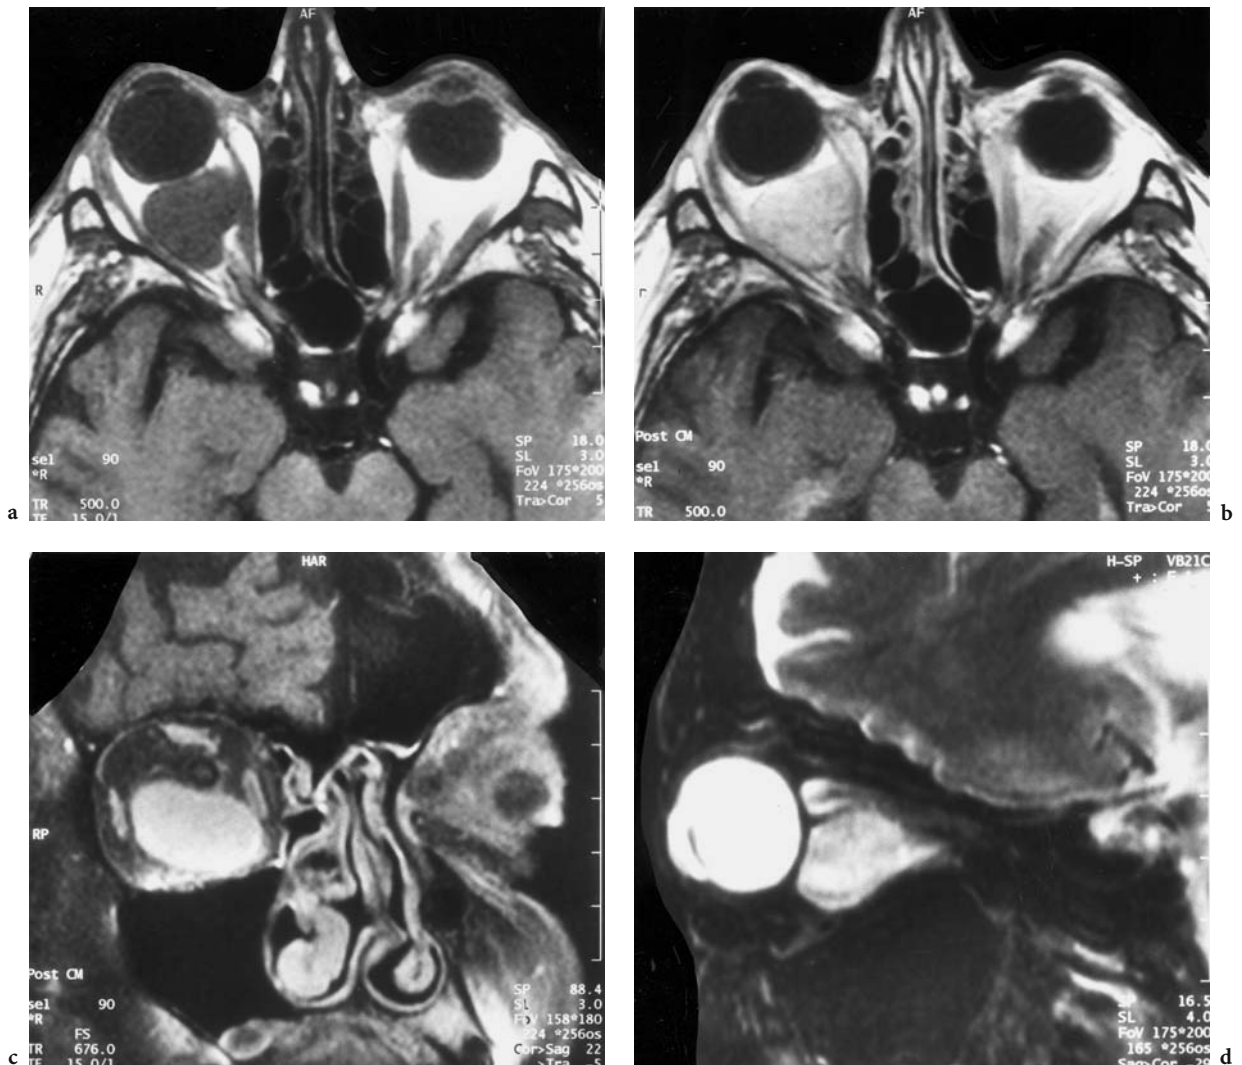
A 68-year-old man with exophthalmos of the right eye. Diagnosis: cavernous hemangioma. MRI: a Axial T1-weighted native image with a sharply outlined, lobulated, retro-orbital, intraconal tumor and slight protrusion of the right bulb. b Corresponding, contrast-enhanced view with homogeneous enhancement. c Coronal, T1-weighted, contrast-enhanced (FS) cut at a right angle to the optic nerve demonstrating the infraoptic location and entire width of the tumor (coronal angle perpendicular to the optic nerve). d Parasagittal T2-weighted view with inferior impression and compression of the optic nerve together with a widening of the anterior subarachnoid space of the optic nerve sheath
